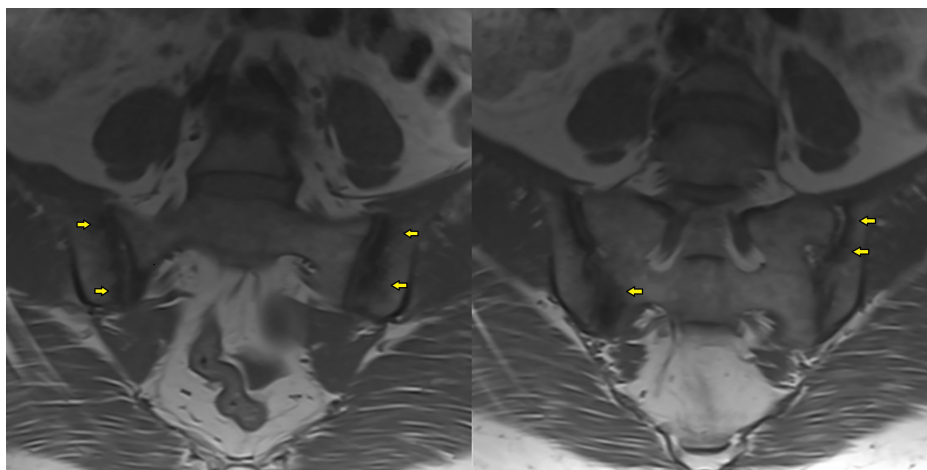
T1-weighted coronal plane images indicate bilateral subchondral sclerosis with hypointense signal in both sacroiliac joints (yellow arrows show the hypointensity representing subchondral sclerosis).
